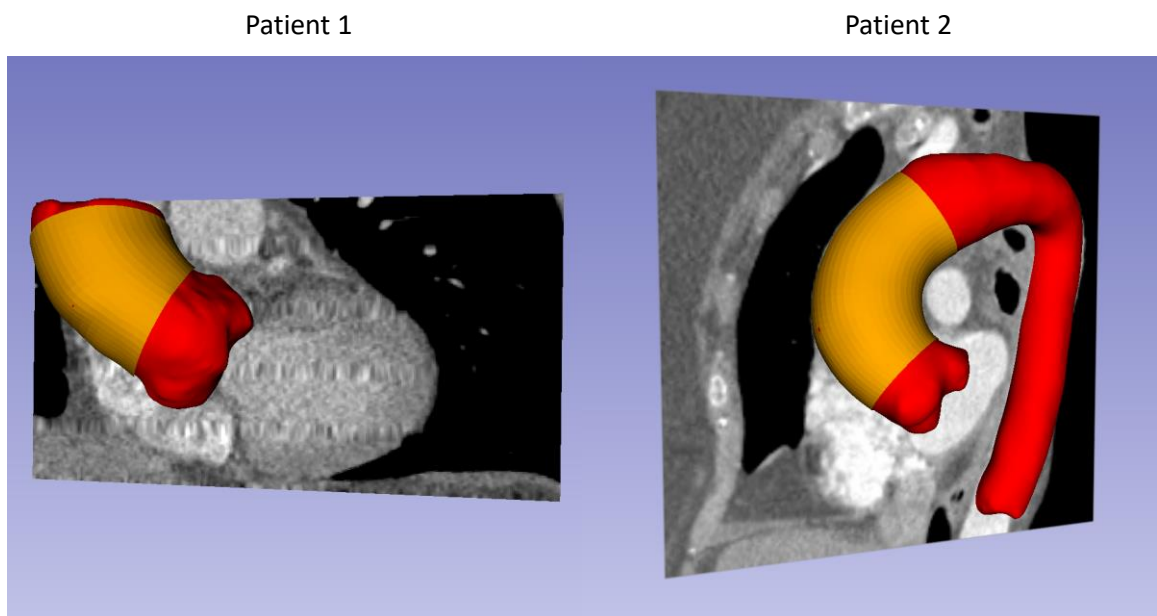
CT image segmentation of the aorta (red) and ATAA segment (yellow) for the two patients.
